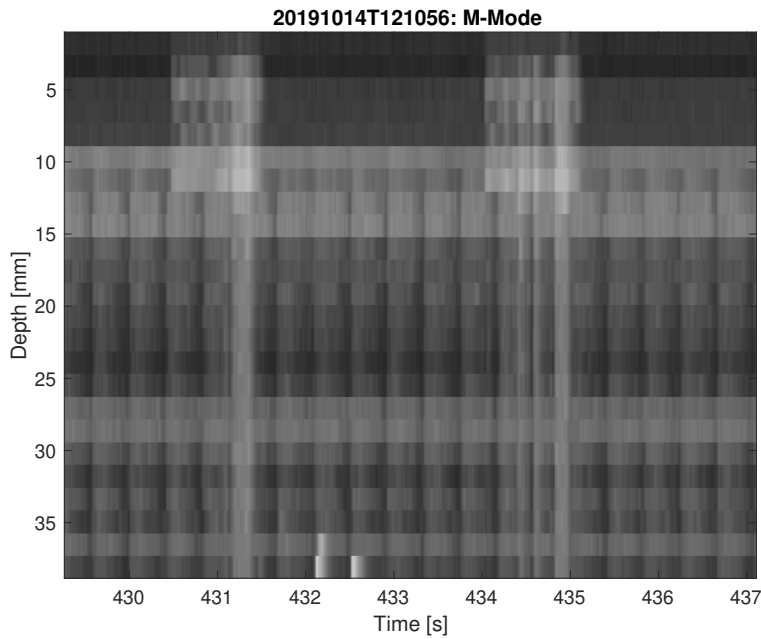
Color M-Mode (CMD) of a ultrasound signal containing artifacts and bubble. The artifacts are located at around 431 s and 435 s, while the bubbles are located between 432 and 433 s.
